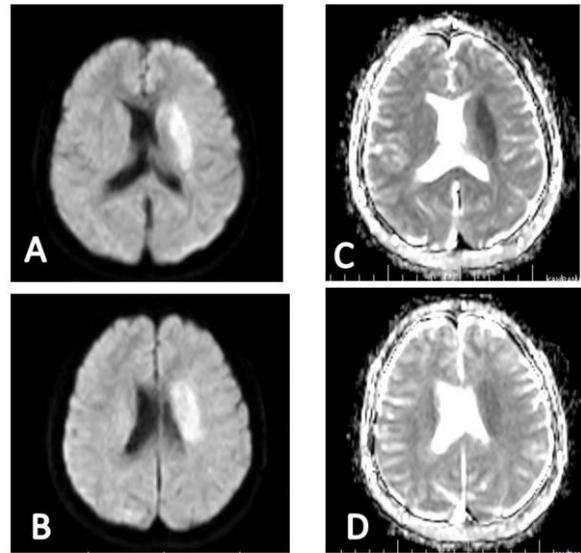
Figure Ia-d. In diffusion (b: 1000 s/mm²) weighted images (a-b) on the MRI taken at the time of application, hyperintensity in the centrum semiovale of the left basal ganglia, and hypointensity in the ADC map (c-d).
